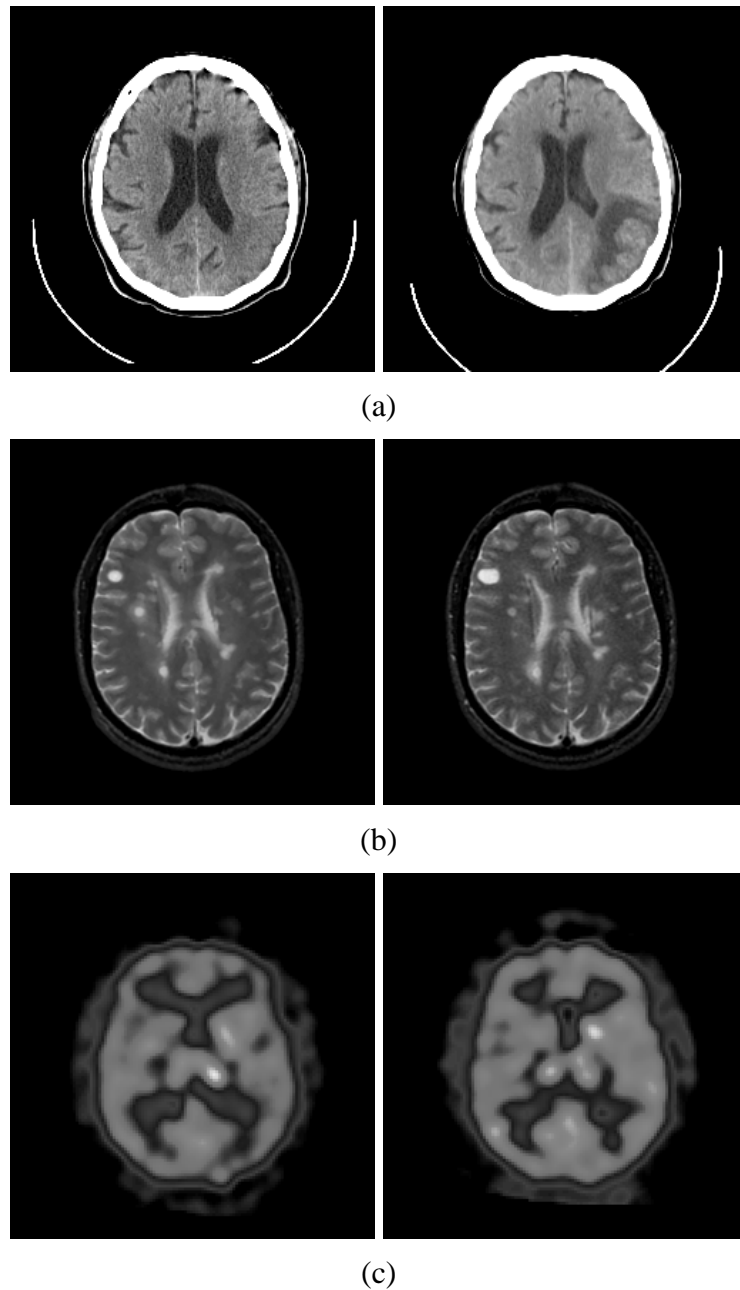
A slice of image series from one individual used in the monomodality registration experiment. (a) CT brain image. (b) MR-T2 brain image. (c) SPECT brain image.
